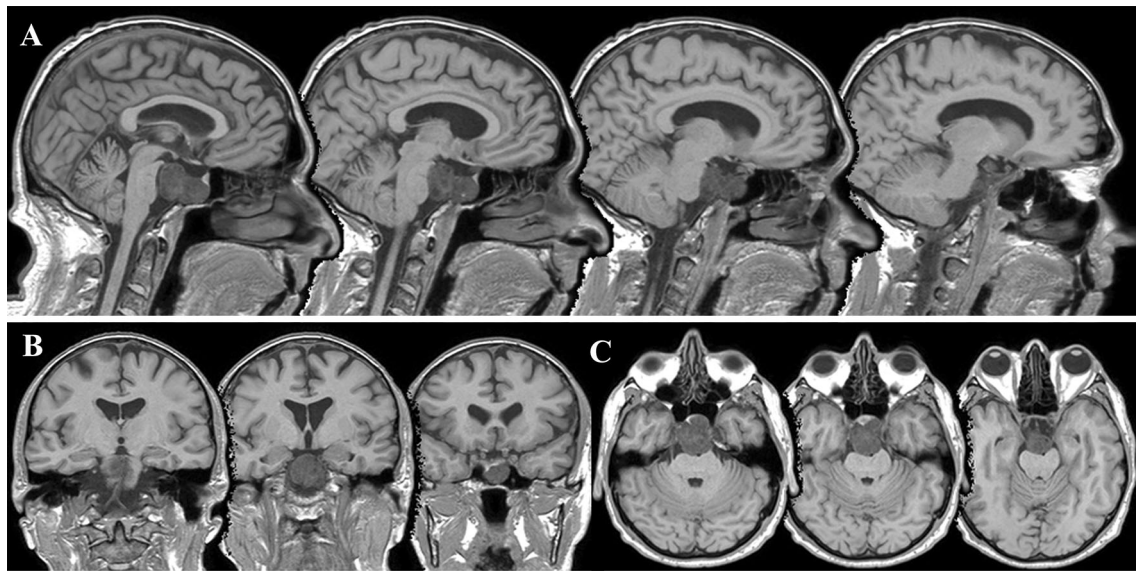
Patient's structural MRI scan exam in the sagittal (a), coronal (b) and axial (c) projections
